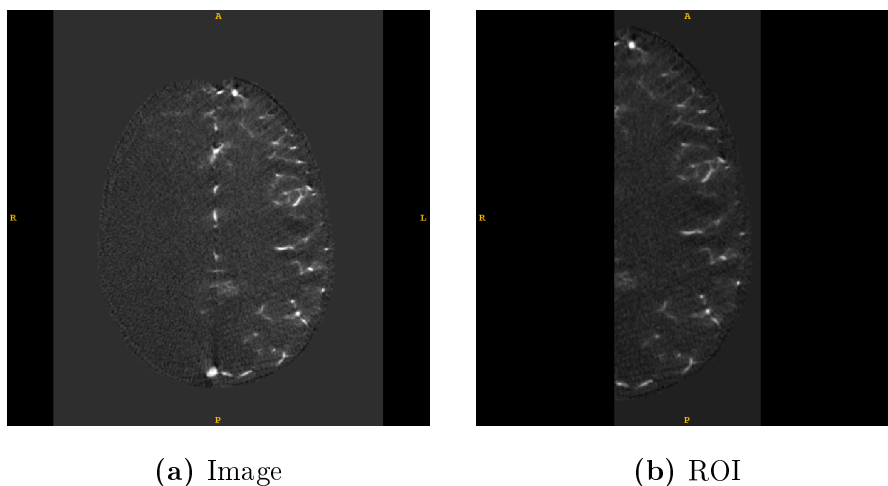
Left: usual CBCT DSA image that contains the whole head of the patient with a hemisphere with enhanced vessels. Right: ROI considered for the segmentation
